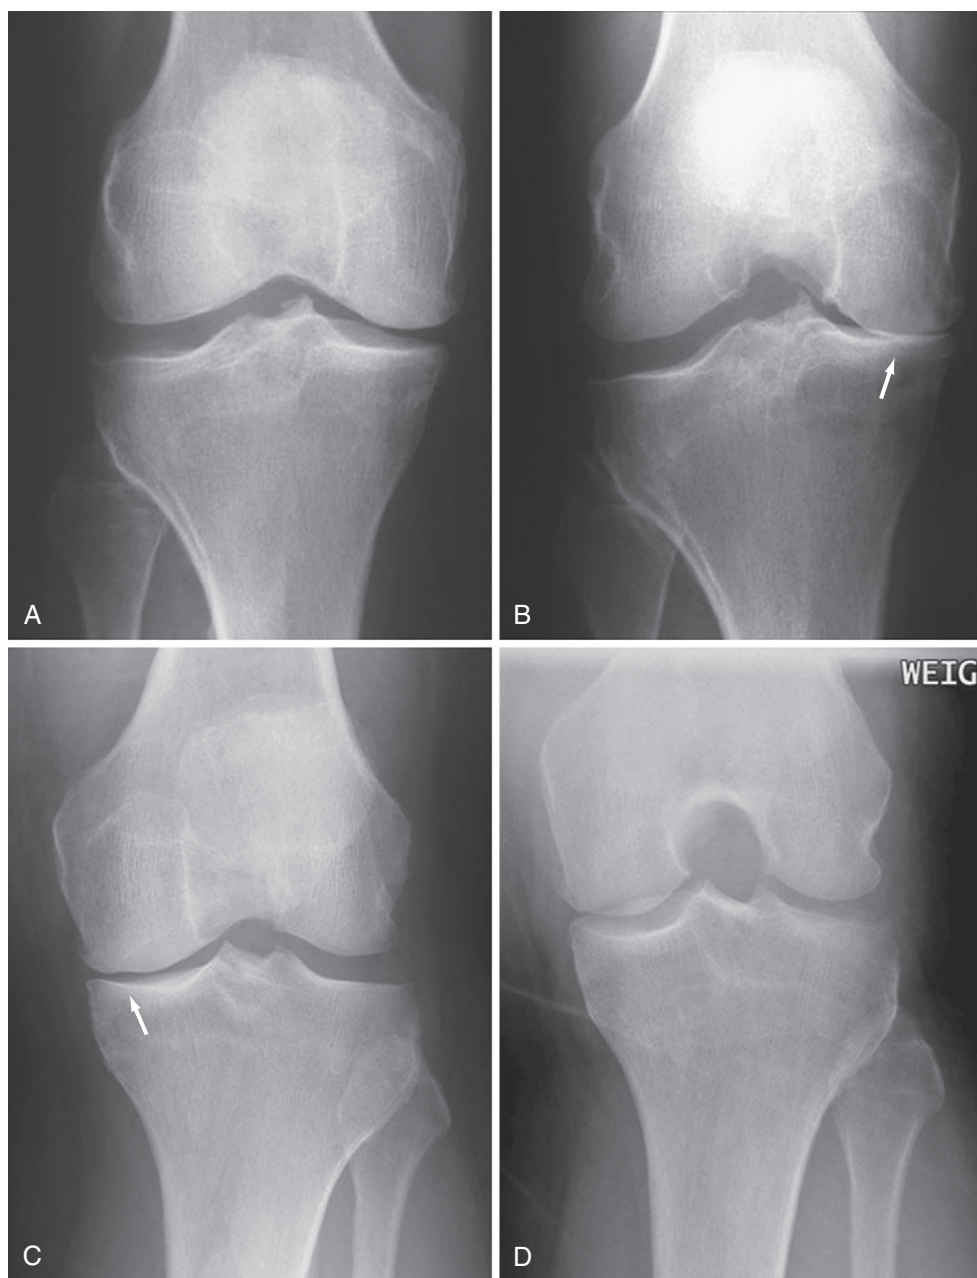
Osteoarthritis of the knee (x-rays). Non-weight-bearing x-rays of the knee frequently underestimate the severity of cartilage loss. A 59-year-old man with pain and suspected osteoarthritis had supine anteroposterior (AP) (A) and erect weight-bearing AP (B) x-rays of the knee. The supine view demonstrates mild osteophytosis and possible subtle joint space narrowing in the medial compartment, whereas on the weight-bearing view, severe medial joint space narrowing is present, indicating severe cartilage damage (arrow). Usually the weight-bearing semi-flexed view is most sensitive to joint space narrowing (cartilage loss), but this is unpredictable. In a 53-year-old man, the erect AP view (C) shows more severe joint space narrowing (arrow) than is seen on the weight-bearing semi-flexed view (D).
